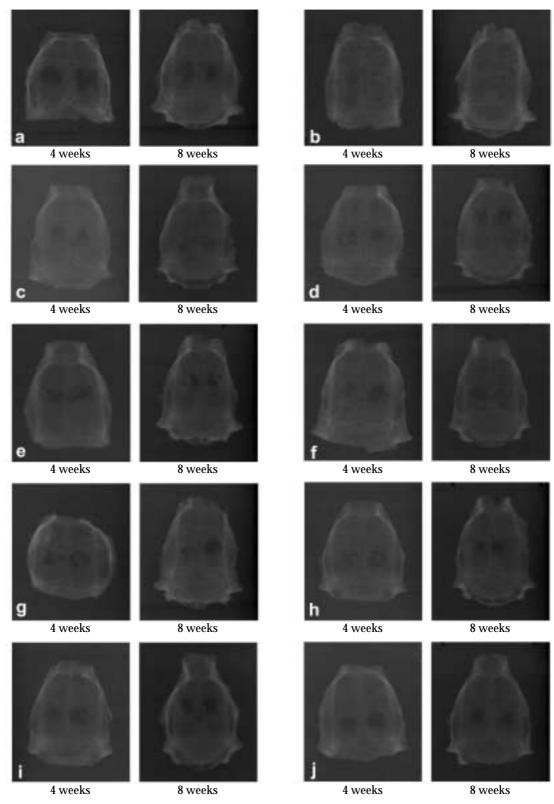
Radiographic appearance of cranial vault, left 4 weeks, right 8 weeks each.
